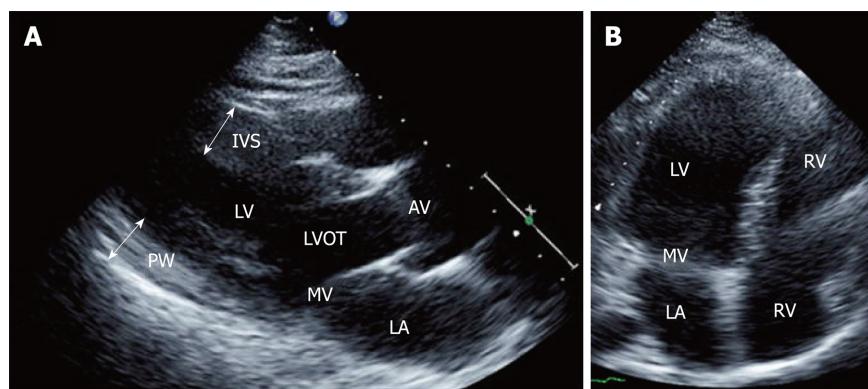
Two-dimensional echocardiographic still frames from a patient with Friedreich's ataxia. A: Parasternal long-axis view showing thickening of the interventricular septum and posterior wall; B: Apical four-chamber view showing dilatation of left ventricular cavity. IVS: Interventricular septum; PW: Posterior wall; LV: Left ventricle; LA: Left atrium; MV: Mitral valve; AV: Aortic valve; LVOT: Left ventricular outflow tract.
